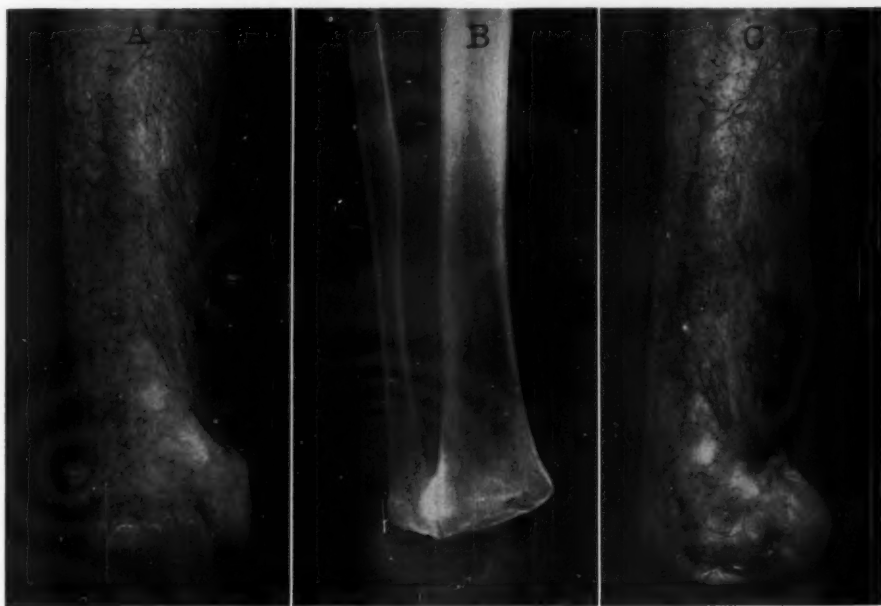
Oblique transection of lower end of tibia results in displacement of heel pad to high side. *A*, The stump when no weight is upon it; the heel pad is displaced medially. *B*, Radiograph of stump; tibia transected obliquely, higher on the medial than on the lateral side. *C*, The stump bearing weight; the heel pad is markedly displaced to medial side. The function of this heel flap (which already is unstable and misplaced) is impaired still more by the displacement which occurs when weight is borne upon it. This is the result of oblique section of lower end of tibia.
